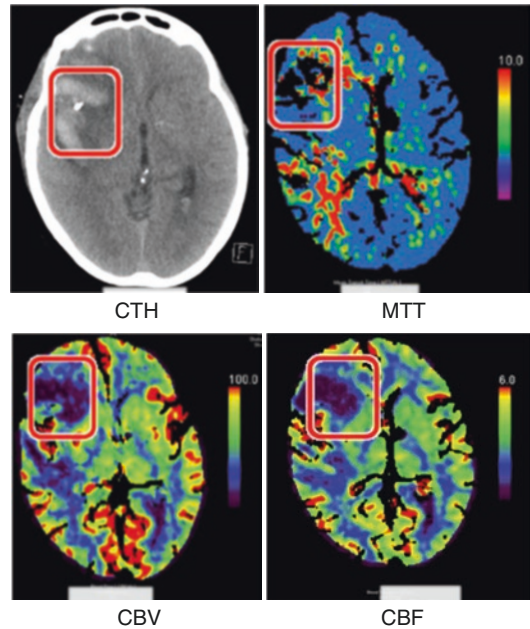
CT head and CT perfusion parametric maps, demonstrating an area of reduction of both CBV and CBF compatible with cerebral infarction
